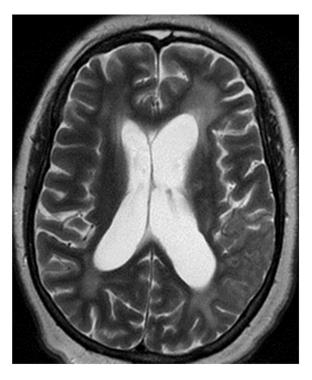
Axial T2-weighted sequences at the level of lateral ventricles showing dilatation of these structures.
